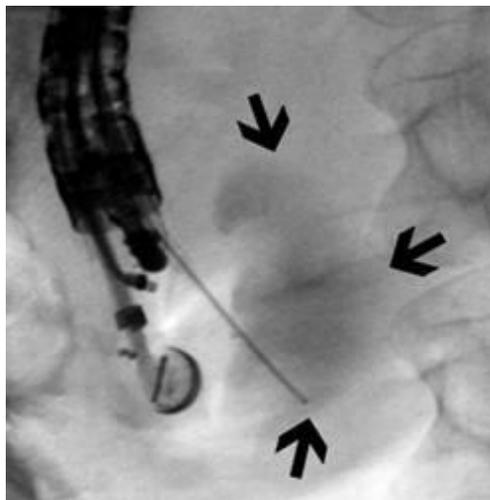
EUS-FNA for pancreatitis diagnosis (CT-image) [53].
